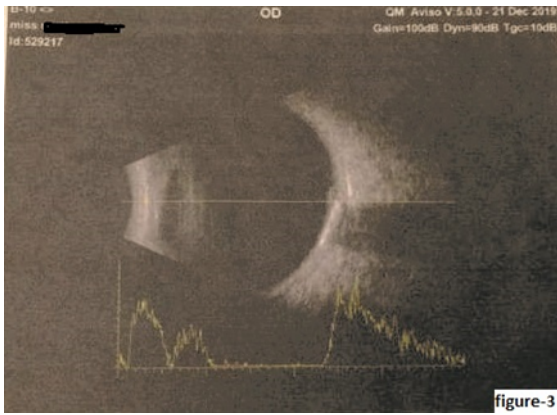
Ultrasonography- B-scan demonstrated a relatively echolucent vitreous and a flat elevated choroidal lesion
